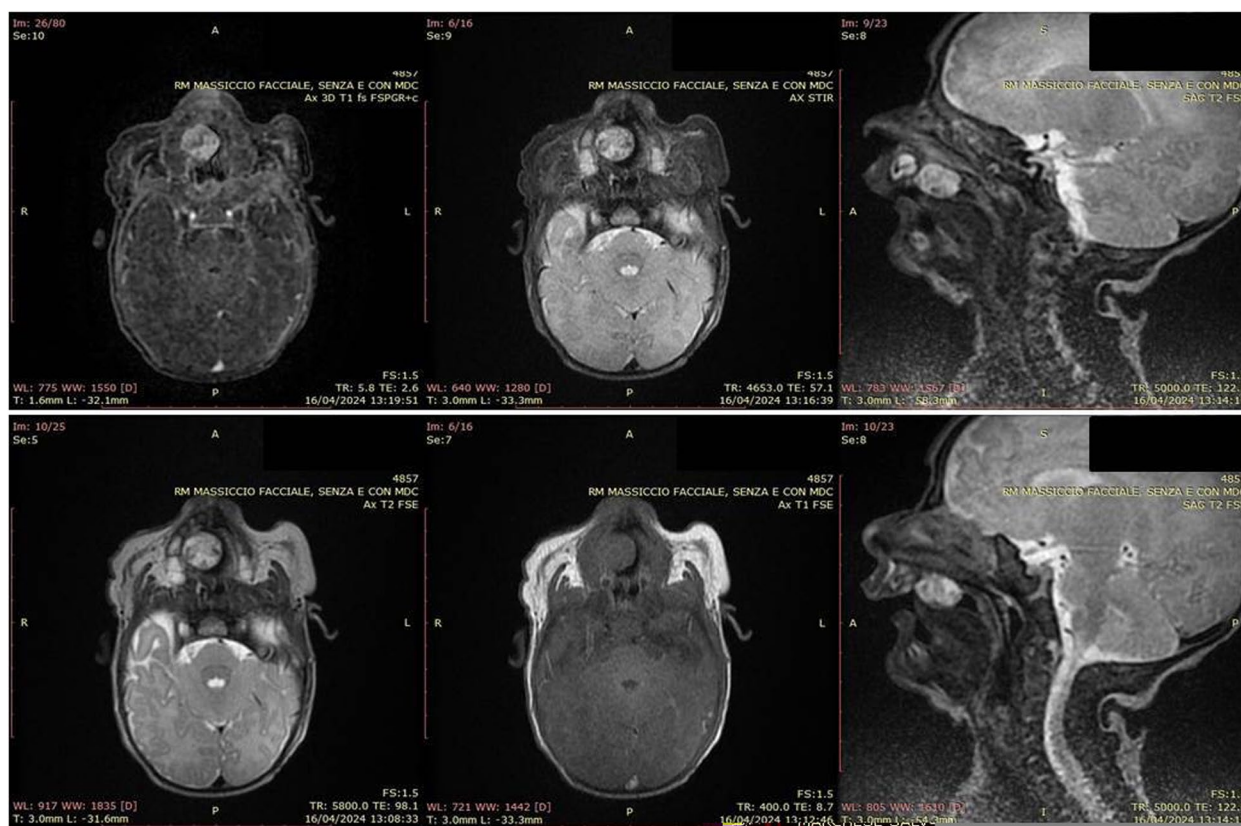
MRI appearance of the palatine IH. The lesion appears as a huge mass involving the maxillary bone, but mainly growing within the oral cavity. A strict relation between the mass and the tongue should be highlighted, which could have been implied in the ulceration and bleeding of the mass
